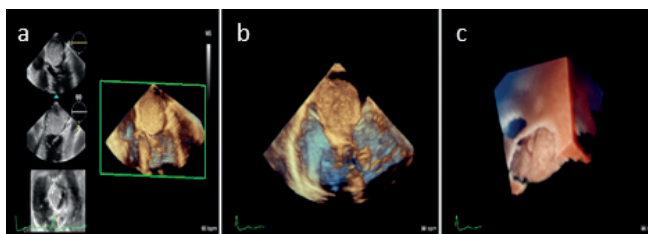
Transoesophageal echocardiography images. A) Midesophageal 0-degree view of the mass B) Midesophageal 0 degrees 3D view of the mass C) Midesophageal 4-chamber 3D True View cropped looking at the myxoma peduncle.
